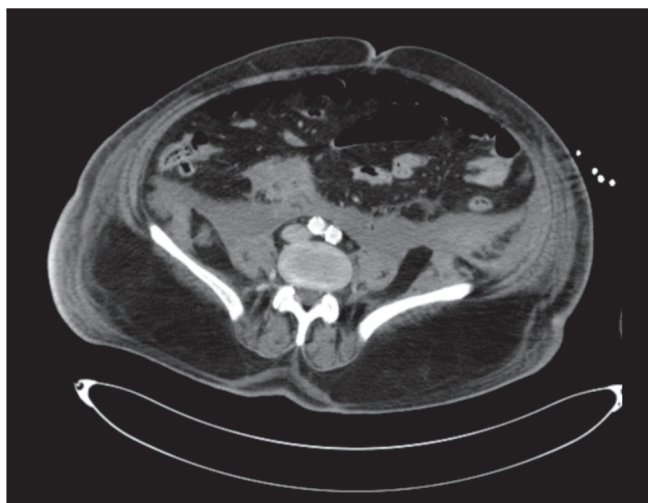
CT image in which preoperative hemoretroperitoneum is observed.
